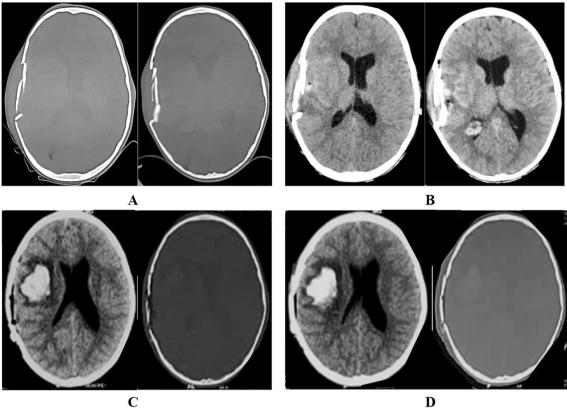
A–D A child presented after road traffic accident with GCS (14/15). A Initial CT (bone window), showing right parietal depressed skull fracture; B Initial CT brain showing small cerebral contusion; C Immediate (0–1 h) postoperative CT brain and bone window showing good elevation of bone chips but with the development of new intracerebral hemorrhage, patient didn't require second surgery; D Follow-up CT after 24 h was the same as the first postoperative CT. This patient had good discharge outcome
